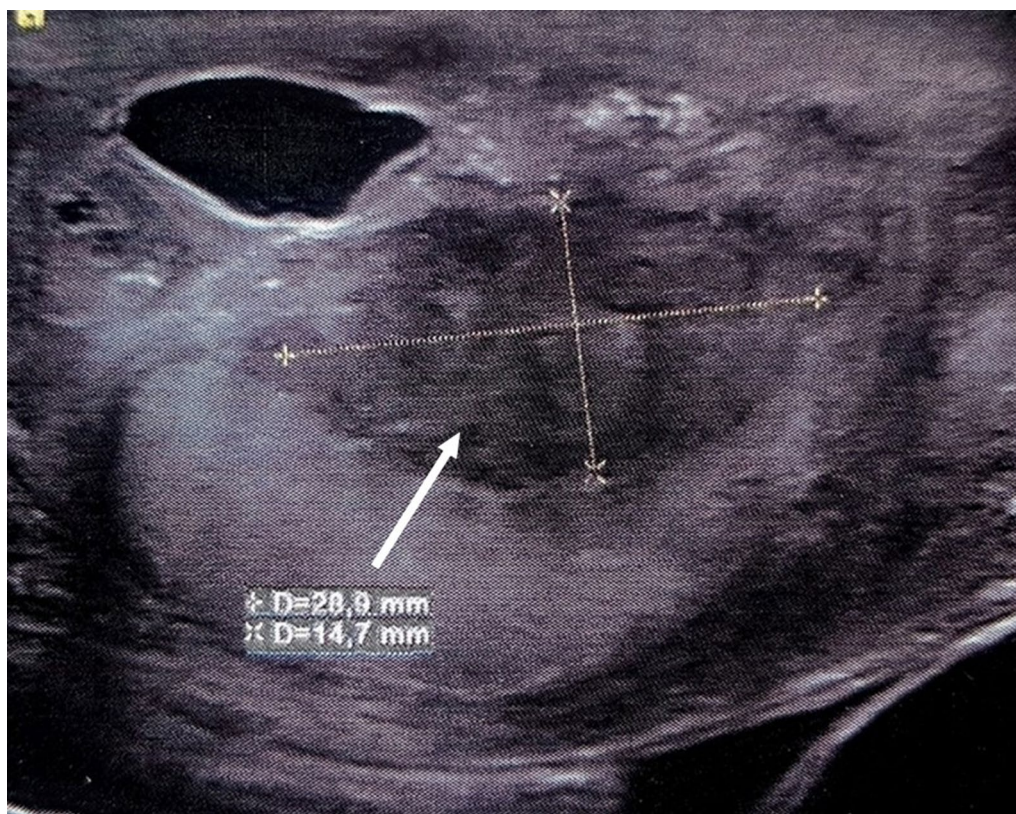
Ultrasonography of left testis showing a heterogeneous and hypoechoic mass measuring 28.9 × 14.7 mm in diameter
